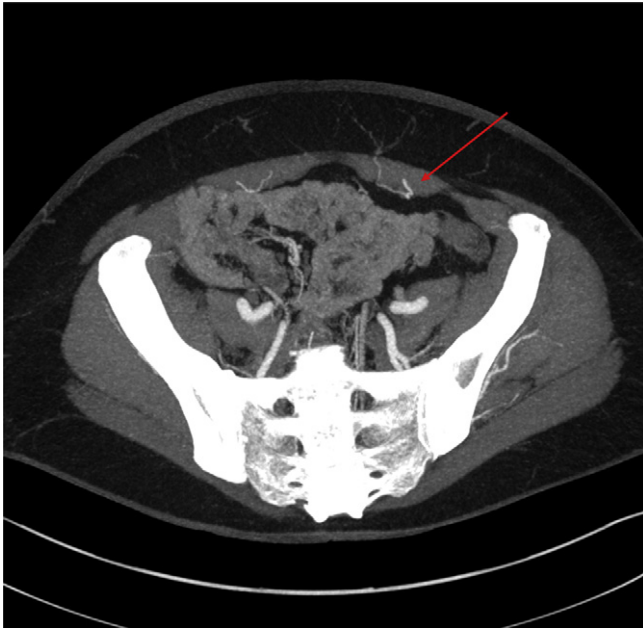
CT angiography (patient 1) showing a large, patent, left-sided deep inferior epigastric artery perforator.
